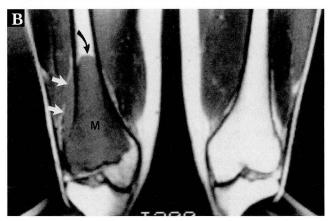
(A) Spin density intermediate weighted (TR 2000, TE 20) axial spin-echo MRI at the same level as Figure 3. (B) T1-weighted (TR 600, TE 20) coronal spin-echo MRI. Abnormal signal (M) replaces the normal marrow fat of the right distal femur and extends into the soft tissues (straight arrows). Note the sharp delineation of lesion extent in both, especially the proximal margin on the coronal T1-weighted image (curved arrow).
